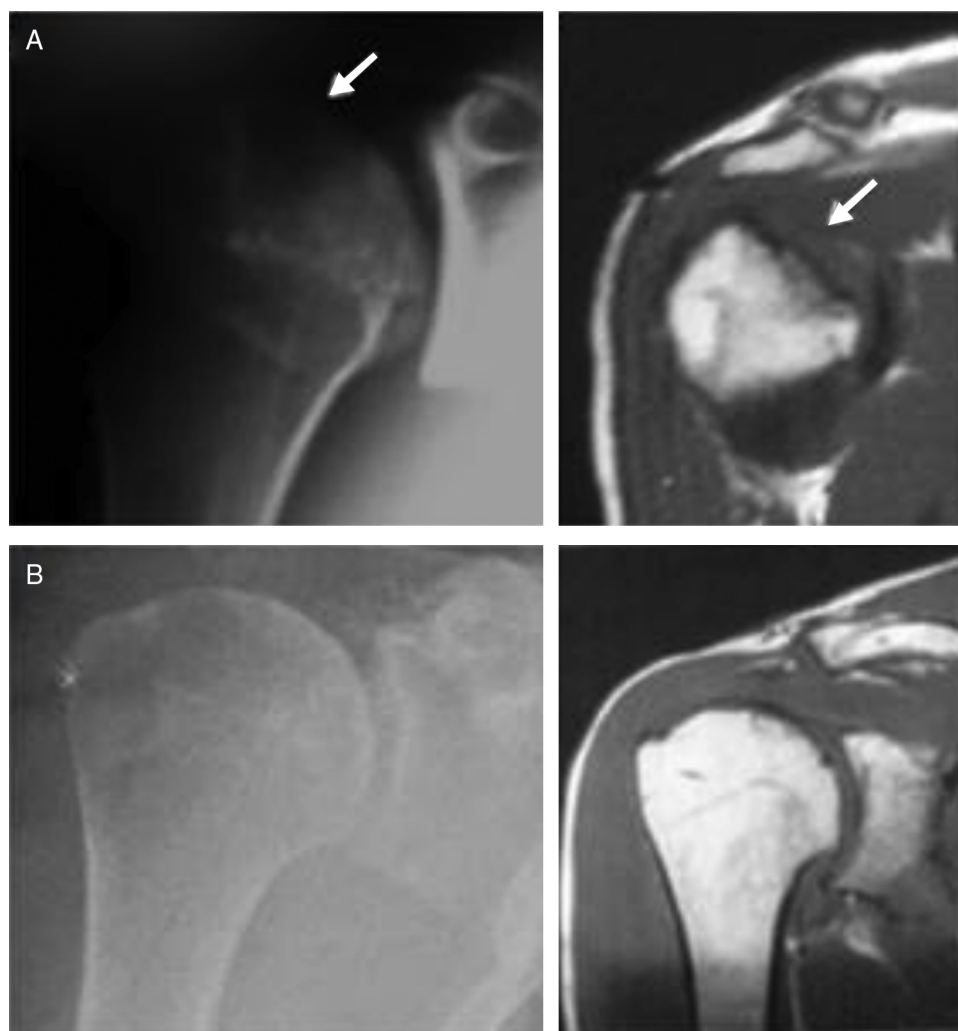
(A) Radiographic images in anteroposterior view and coronal T1-weighted enhanced magnetic resonance imaging of the right shoulder of case 3 in the preoperative period, demonstrating the area of necrosis (see arrows); (B) radiographic images in anteroposterior and coronal T1-weighted enhanced magnetic resonance imaging of the right shoulder of the same case, demonstrating total graft integration after 15 years follow-up.
